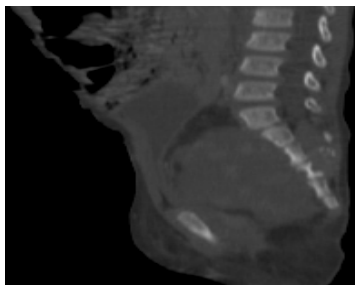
Sagittal Bone window CT images of pelvis show erosion of posterior elements of sacrum.
